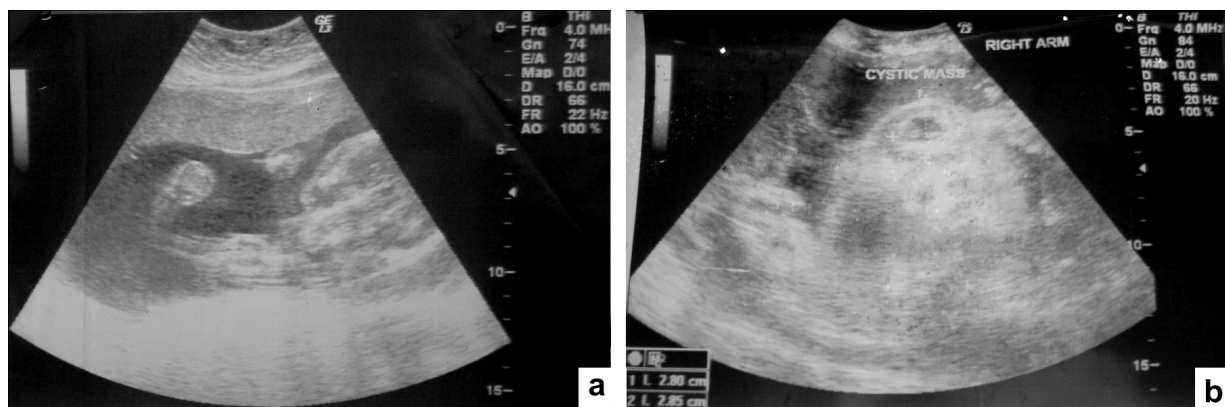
Antenatal ultrasonogram at 37 weeks' gestation showing (a) a single live intrauterine fetus with cephalic presentation, longitudinal lie and flexion attitude. A cystic swelling is seen arising from right arm, (b) the size of the arm swelling measures 2.80×2.85 cm.
